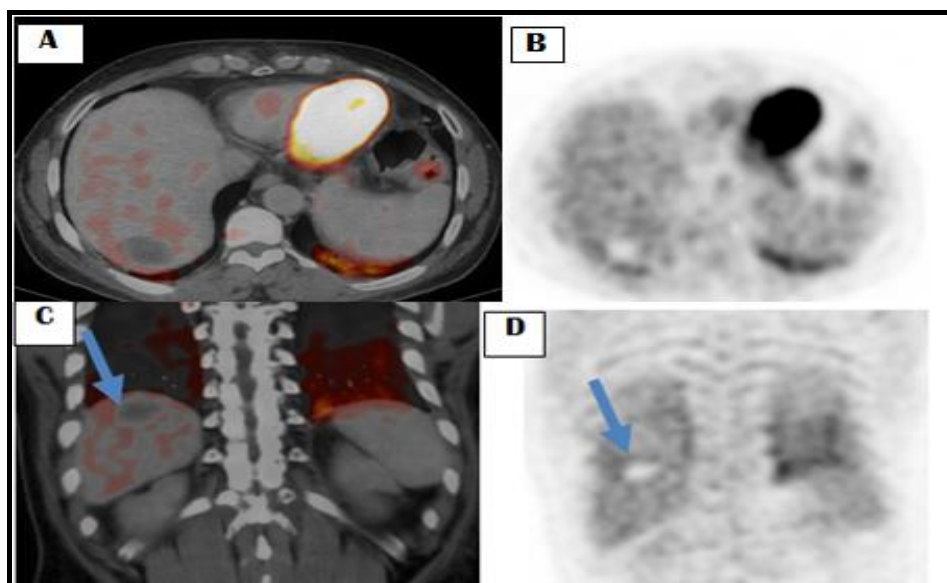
51 years old male patient with history of HCC diagnosed with typical enhancement criteria of HCC by triphasic CT and elevated alpha feto protein (98 ng/ ml) underwent radiofrequency ablation, referred for PETCT I month later after RFA.
